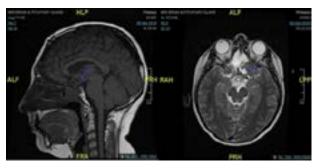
Post-radiotherapy coronal T2-weighted post gadolinium comparative images showing a significant reduction in tumour volume.
